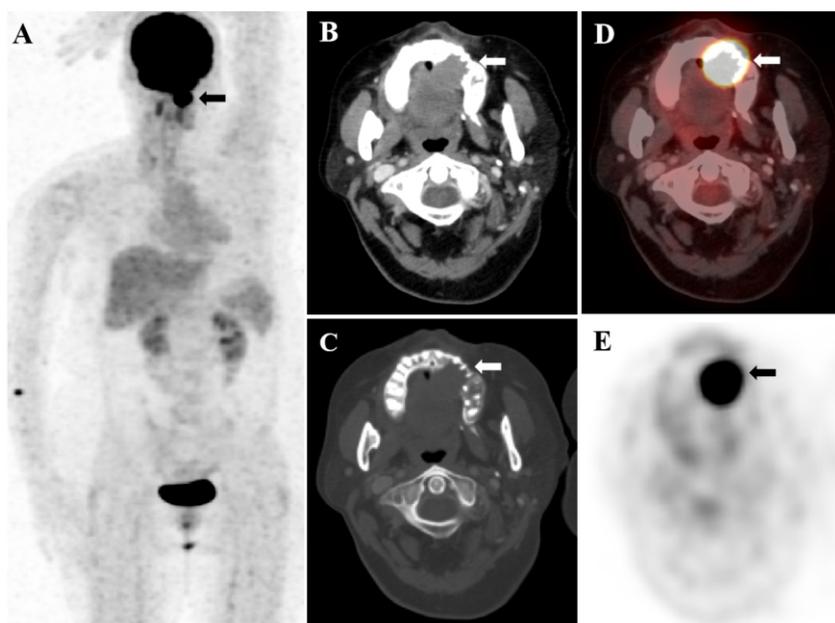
Fluorine-18-FDG PET/CT imaging of maxillary lesion. Maximum intensity projection (MIP) (A), axial contrast enhanced CT imaging on soft tissue window (B), bone window (C), PET/CT fusion imaging (D) and PET imaging (E) revealed a solitary lesion in the maxilla with increased ¹⁸F-FDG uptake.
